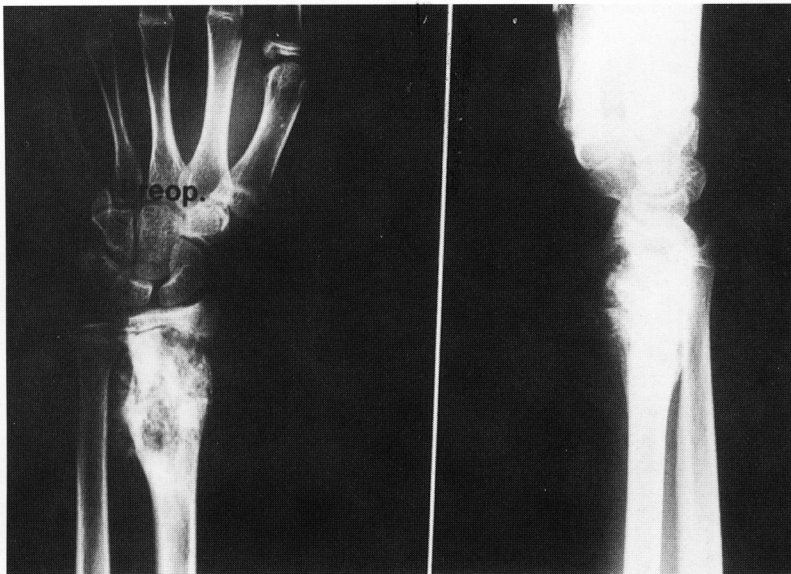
Simple X-ray shows osteoblastic lesion on distal radius with margination of tumor due to chemotherapeutic effect.
